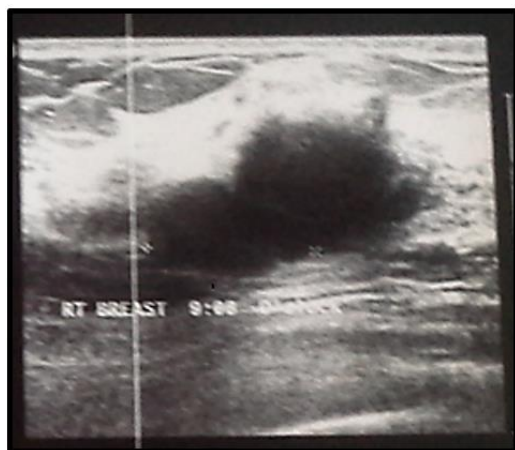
Ultrasound of Right Breast shows Irregular Mass of Size 2x1 cm with Altered Echotexture
